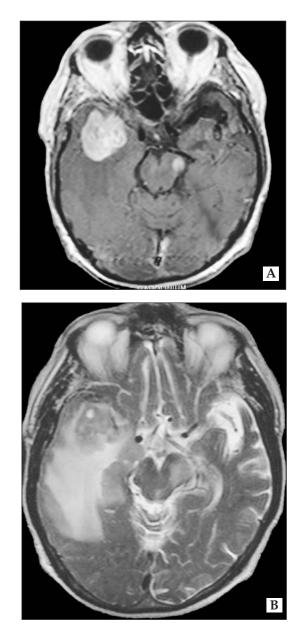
Axial T1 Magnetic Resonance Imaging (MRI) with contrast enhancement
